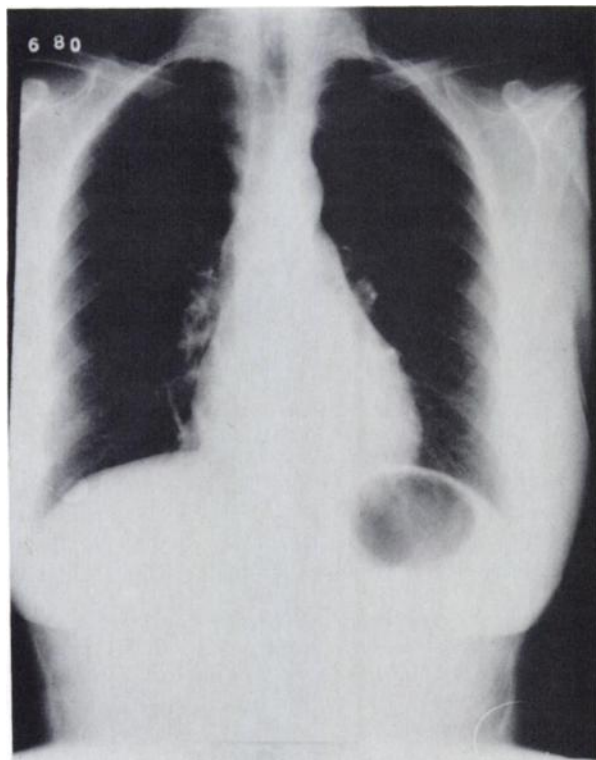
Follow-up radiograph showing clearing of the lower-lobe infiltrates.
